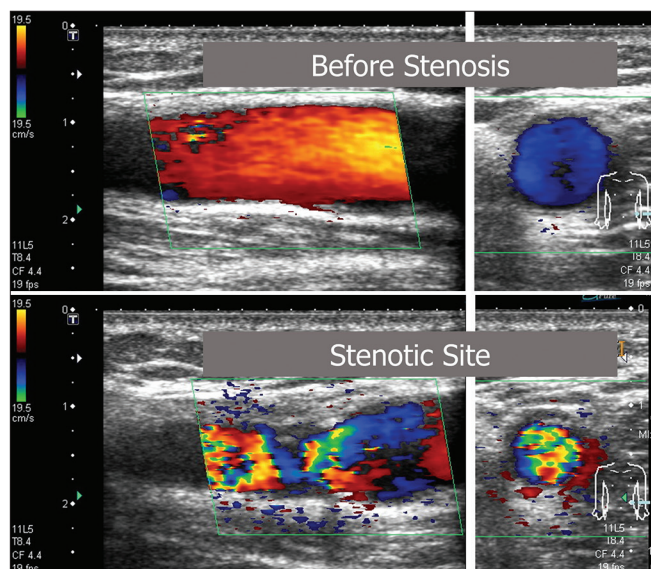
The lower part of the figure shows an “aliasing phenomenon” at the stenotic site. A bruit artifact is produced, indicating that the blood flow velocity increased significantly and exceeded the maximum velocity scale of the color Doppler-mode
